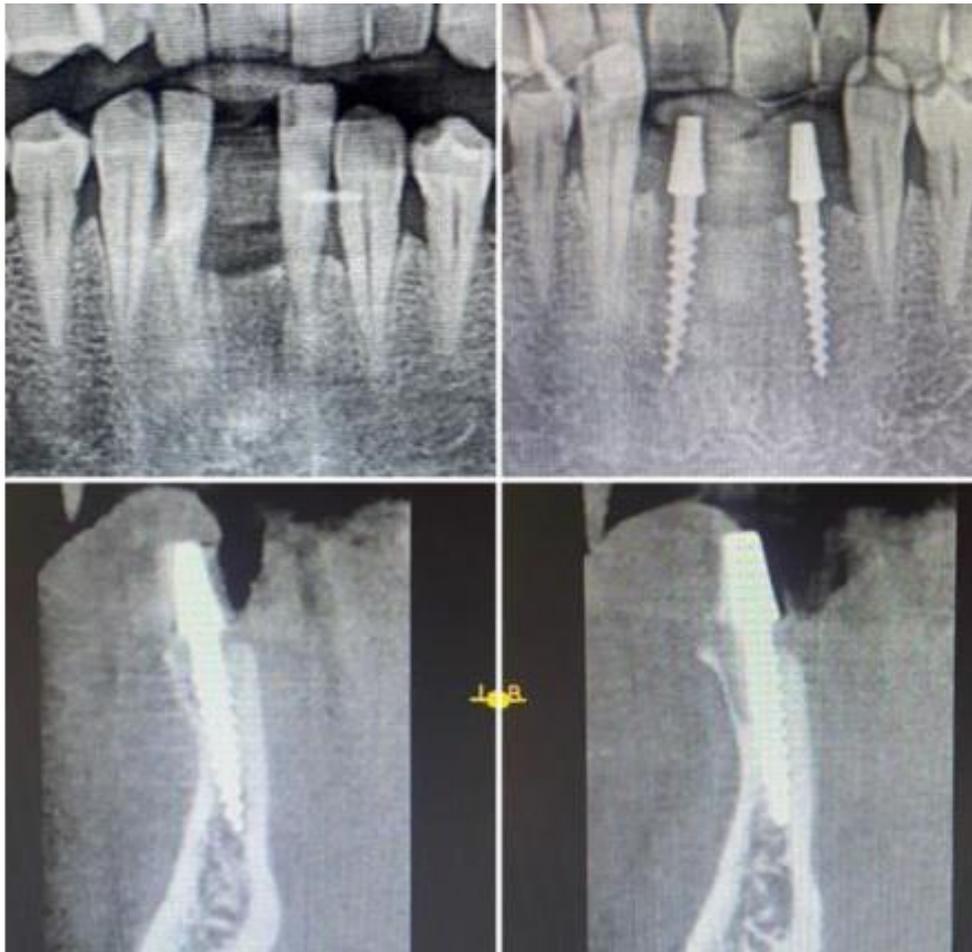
Radiograph of lower jaw before and after surgery
